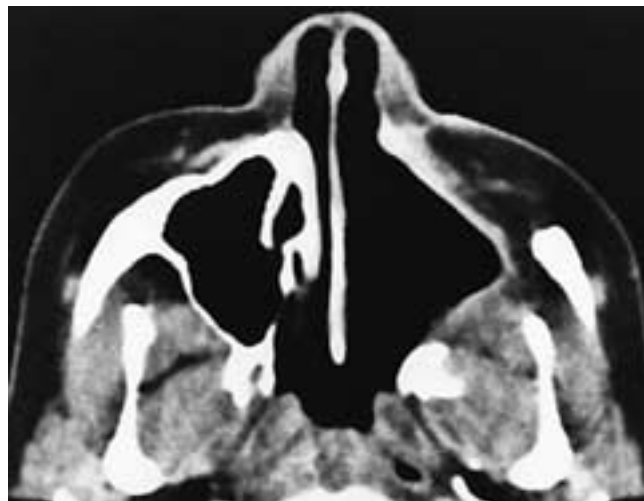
Axial CT scan on a patient who has had a total left maxillectomy. The postoperative cavity is smoothly lined with thin soft tissue from a split-thickness skin graft. This is the normal appearance of a total maxillectomy. The pterygoid plates were not resected in this patient.
